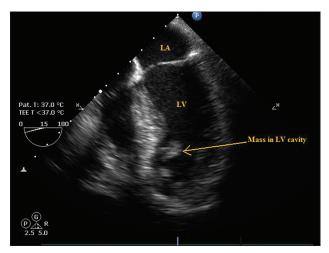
Midesophageal four chamber view of tranesophageal echocardiography showing left ventricular mass
